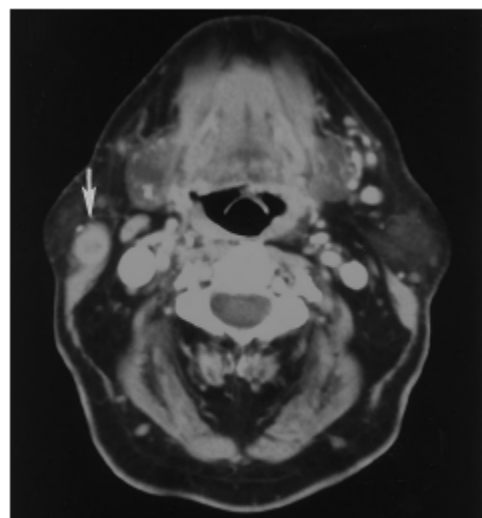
Contrast-enhanced neck CT scan shows high-attenuation right parotid adenopathy from MCC (arrow).
